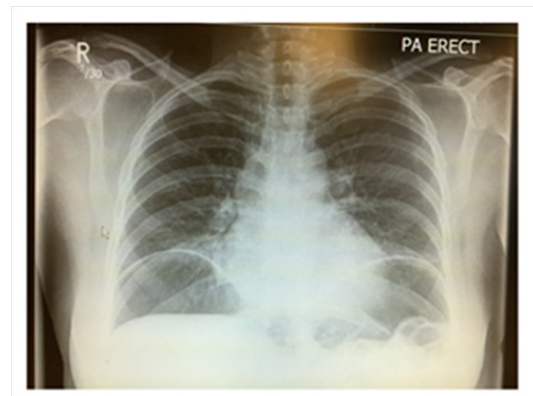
Chest X-ray showed air under the diaphragm.
